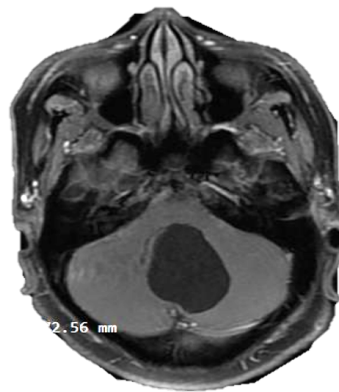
T1-weighted MRI Scan showing a hypointense lesion in the posterior fossa
